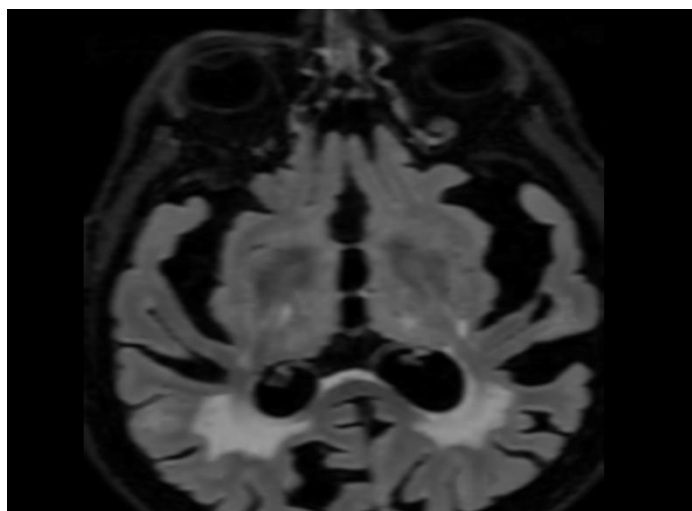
MRI image FLAIR sequence axial section shows hyperintense signal and atrophy of splenium of corpus callosum
